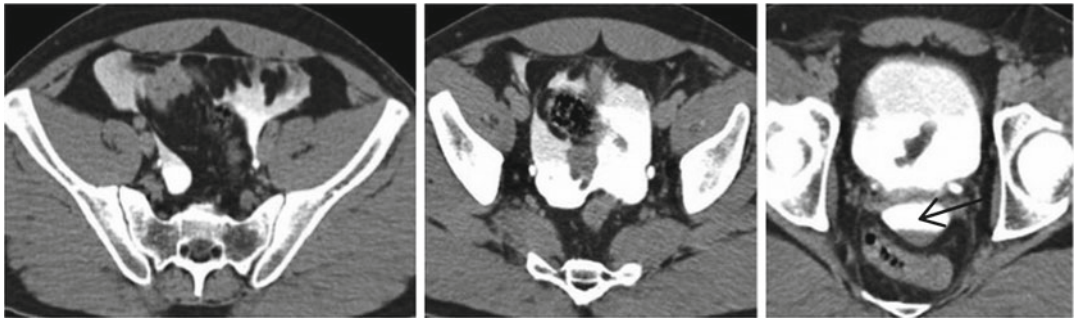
CT cystography of an intraperitoneal bladder injury. Free Intraperitoneal fluid surrounding bowel loops, indicating an intraperitoneal bladder injury. Also note fluid in cul de sac (*arrow*)
